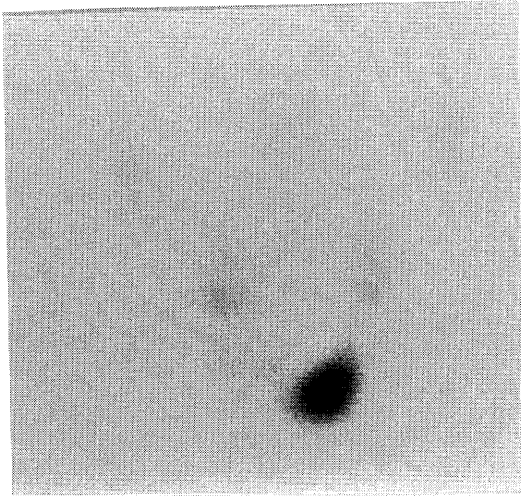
Anterior neck image of thyroid scintigram obtained 20 minutes after 185 MBq ^{99m}Tc -pertechnetate intravenous injection showed the residual thyroid tissue of the left lobe.
